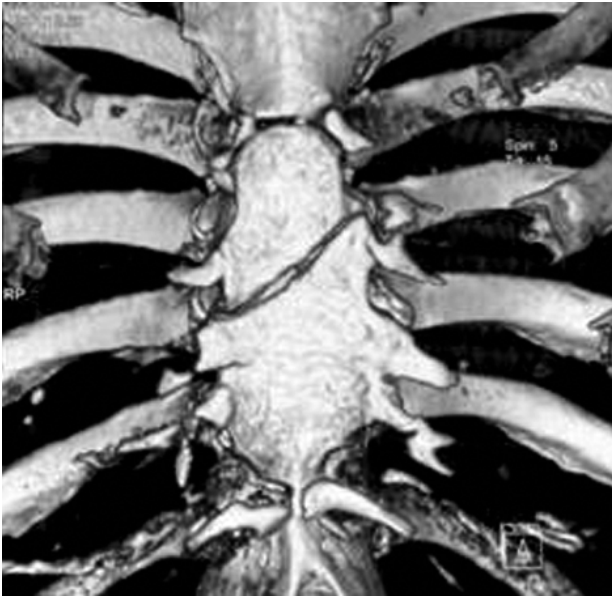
CT scan. Dual source image shows complete transverse sternal fracture with two lines of pseudoarthrosis of the stumps.
